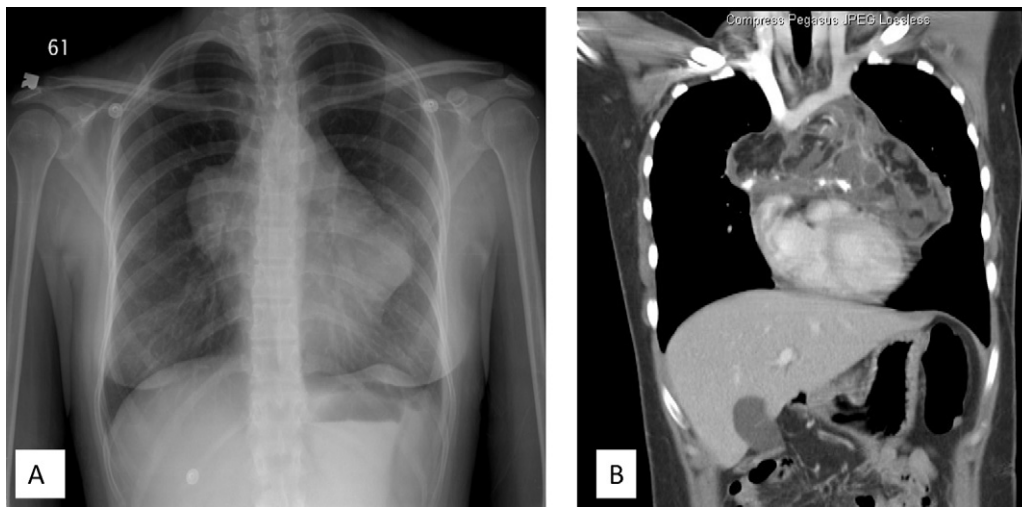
Mediastinal mass on CXR (A) and coronal view on CT scan with appearance of involving the heart and the innominate vein. (B.)
